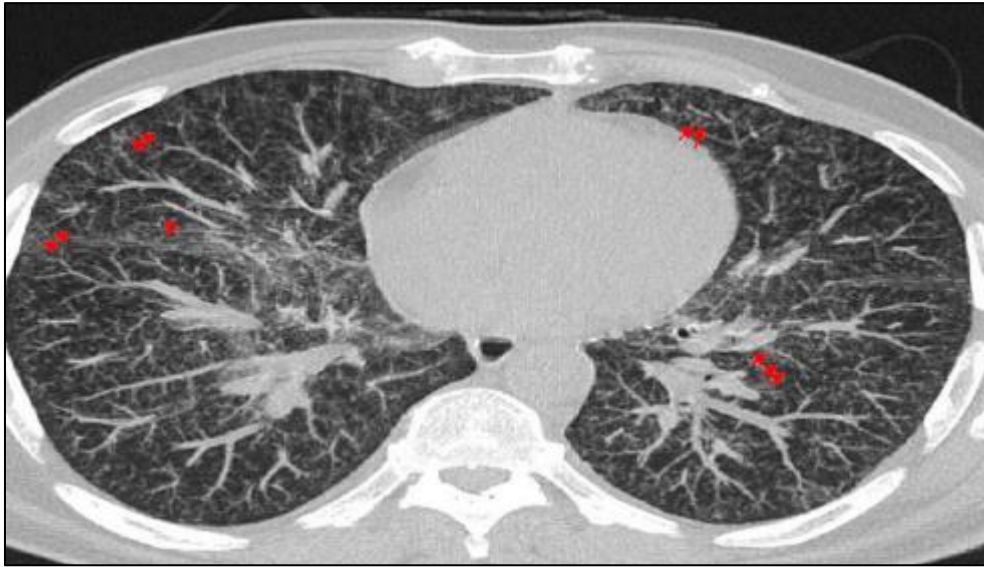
Axial section of thoracic CT scan showing micronodules
